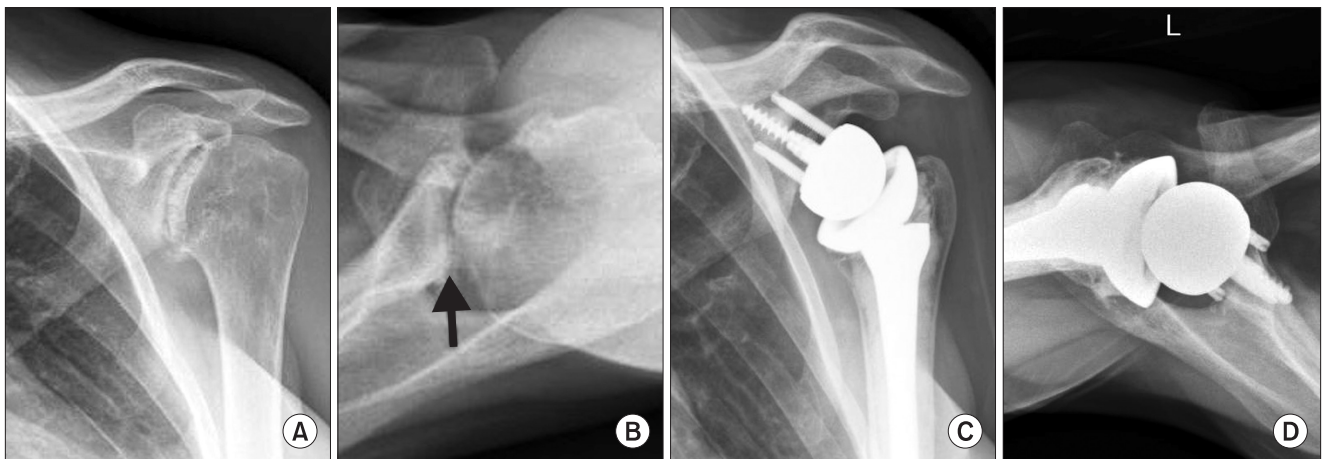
A 53-year-old male patient with osteoarthritis with glenoid bone loss. (A) Preoperative conventional anteroposterior radiograph of the shoulder and (B) preoperative conventional axillary radiograph of the shoulder show severe bony erosion of posterior glenoid (arrow). Postoperative conventional shoulder radiographs at 25 months' follow-up show a well-fixed prosthesis: (C) anteroposterior view, and (D) axillary view.
